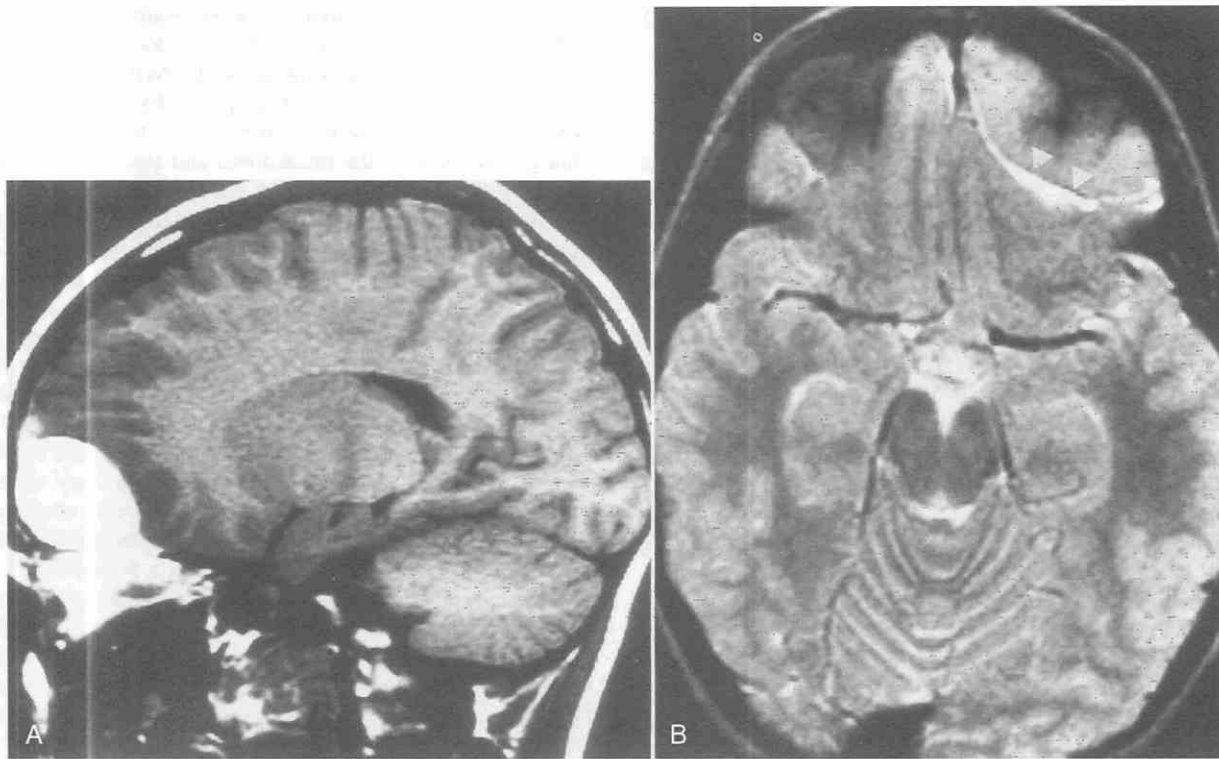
A and B, Sagittal T1-weighted (500/15) and axial T2-weighted (2500/80) MR images show large subacute epidural hematoma overlying the left frontal lobe. Note the displacement of the hypointense dura away from the inner table of the calvarium (arrowheads).
